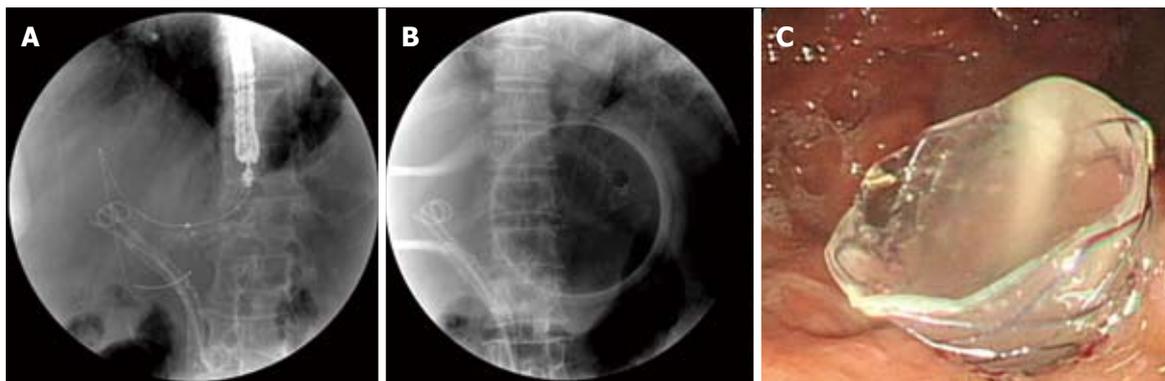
Endoscopic ultrasound-guided hepaticogastrostomy. A: In the intrahepatic approach, the linear array echoendoscope was placed in the lesser curvature of the stomach for viewing the left intrahepatic system. A 0.035-inch guidewire was introduced through the endoscopic ultrasonography-needle and advanced in an antegrade manner; B and C: A fully covered metal stent was placed under echoendoscopic and fluoroscopic view.
